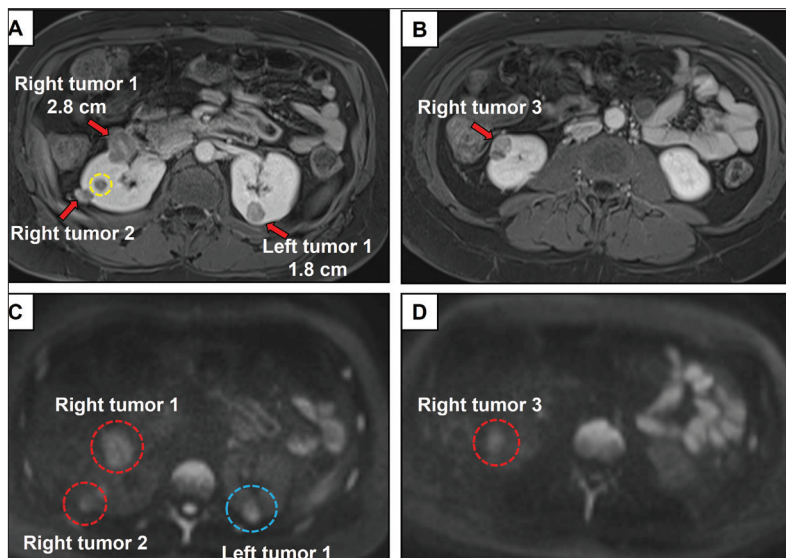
Preoperative MRI axial images showing the three right renal masses that were subsequently removed with partial nephrectomy, and a left renal tumor that is undergoing active surveillance. (A) MRI T2 FS images, right tumors 1 and 2 were in the anterior and posterior midportions of the right kidney, respectively. The yellow dashed circle indicates the small, stable endophytic AML that was not resected, and the arrow points to the left renal tumor that the patient will be undergoing active surveillance. (B) MRI T2 FS image showing right tumor 3 was in the anterior lower pole of the right kidney. (C) MRI showing restricted diffusion is most prominent on right tumor 1 ($b=2000$ s/mm² on 3T MRI) as compared to the right tumor 2, which prompted partial nephrectomy, the light blue dashed circle indicates the small left renal tumor with restricted diffusion. (D) MRI showing restricted diffusion of right tumor #3, which prompted partial nephrectomy. MRI: magnetic resonance imaging.
